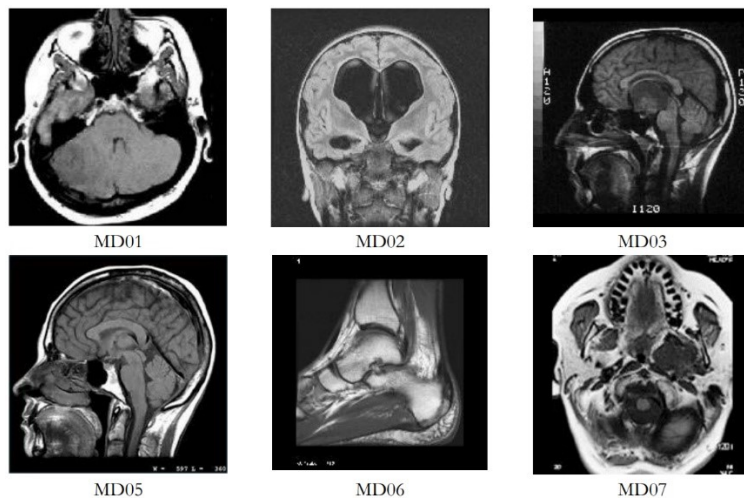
MRI overlay images for EPR dataset embedding.
